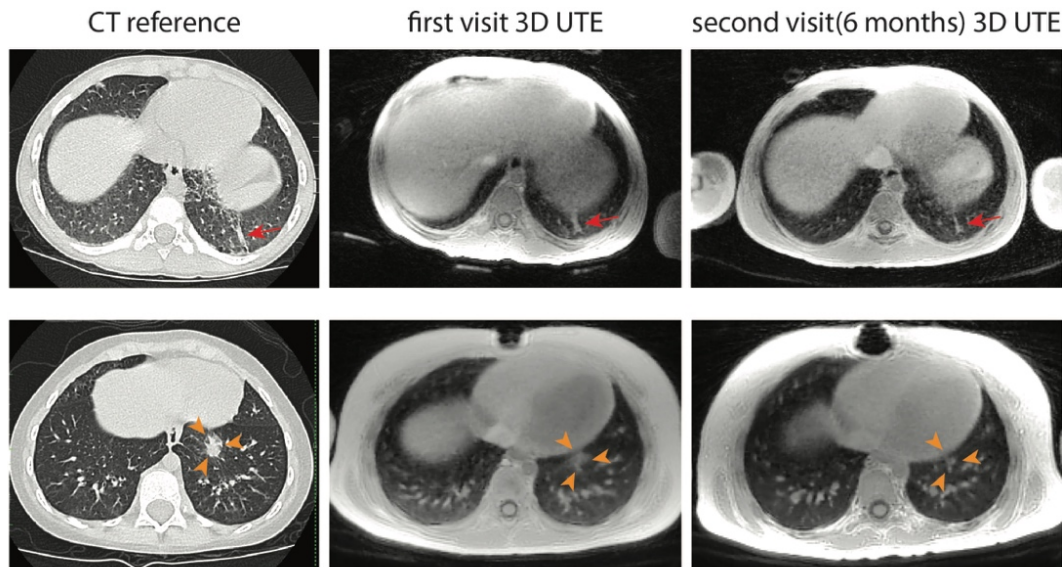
Follow-up studies results. Two pediatric patients got their second MRI exam 6 months after their first MRI, and the CT scans happened around their first MRI exams. For patient 1, septal thickening is pointed out by red arrows. For patient 2, a lung nodule region is surrounded by orange arrows.
